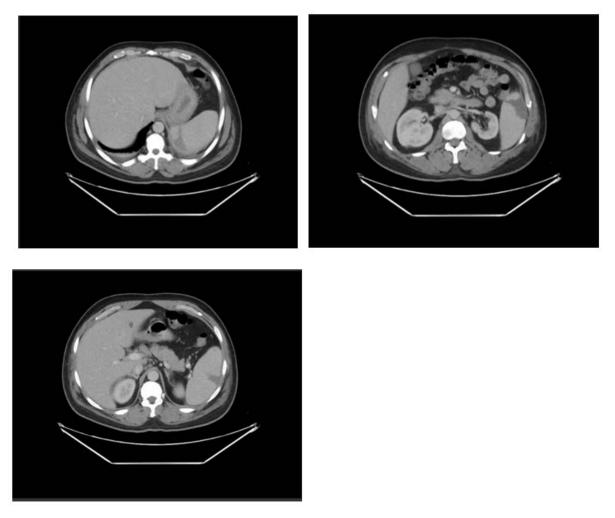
Enhanced CT scan of the abdomen at multilevel showed multiple peripheral wedged shape hypo enhancing lesions seen in the spleen
